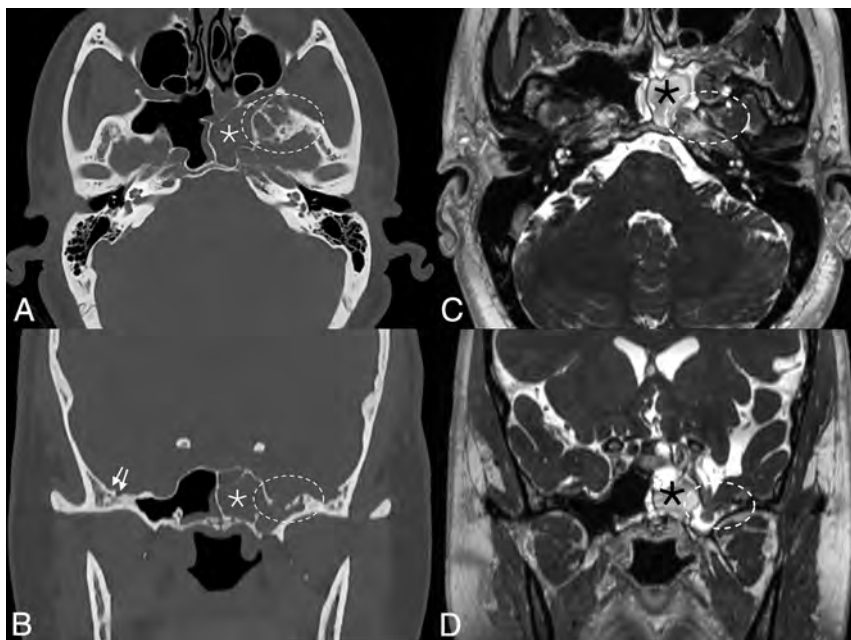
Skull pitting, meningoceles, and CSF leak in a patient who presented with rhinorrhea. Axial and coronal CT images (A and B) demonstrate substantial pitting along the anteromedial aspect of the left middle cranial fossa (dashed ovals, A and B), with complete opacification of the left sphenoid sinus (asterisks), concerning for a CSF leak. Milder pitting is noted on the right (solid arrows). Corresponding MR imaging (C and D) confirms a meningocele protruding into the left sphenoid sinus (dashed ovals, C and D). MRV (not shown) noted smooth tapered stenoses involving both transverse sinuses, and the patient was ultimately diagnosed with pseudotumor cerebri.
